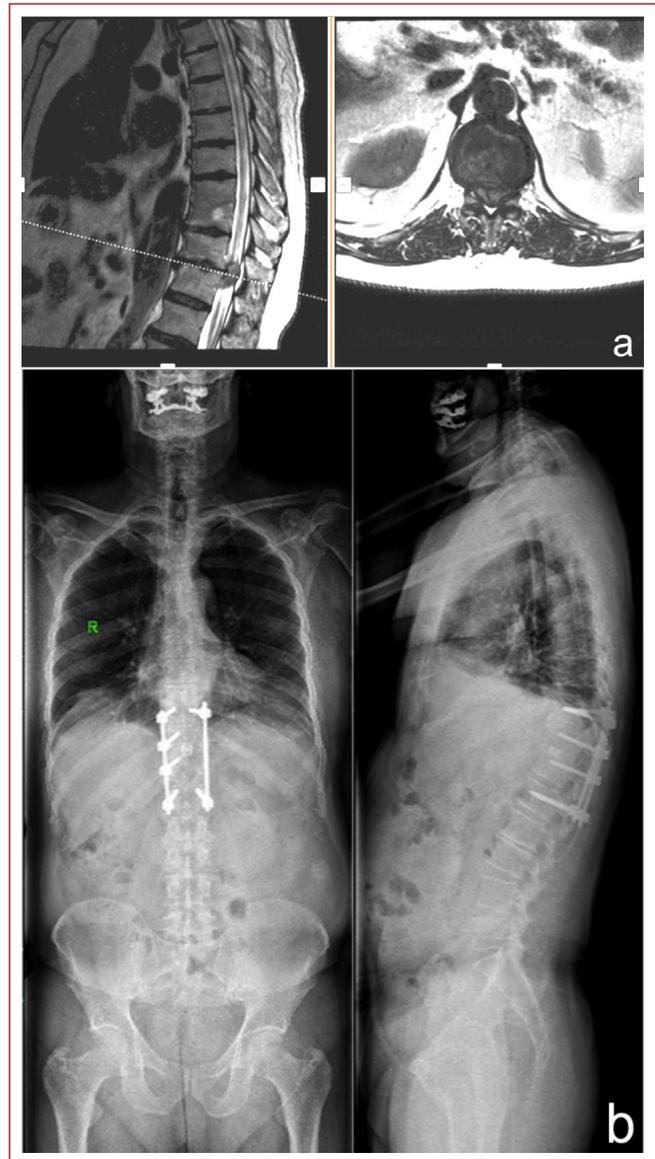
a) Preoperative MRI showing a central disc hernia narrowing the spinal canal at T11–12 level; b) X-ray of the same patient in the first year postoperatively.
